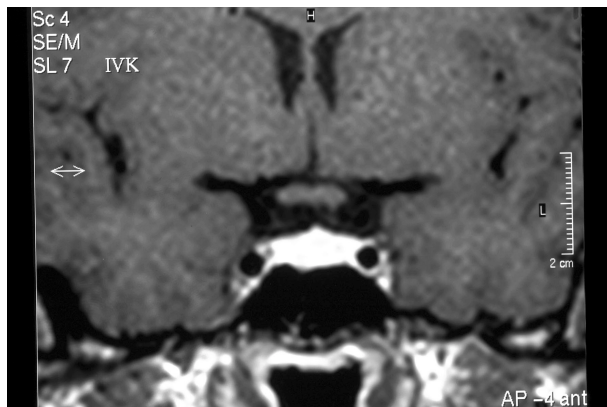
MRI image of the pituitary gland in hypothyroid state. The gland volume is enlarged in both size.
